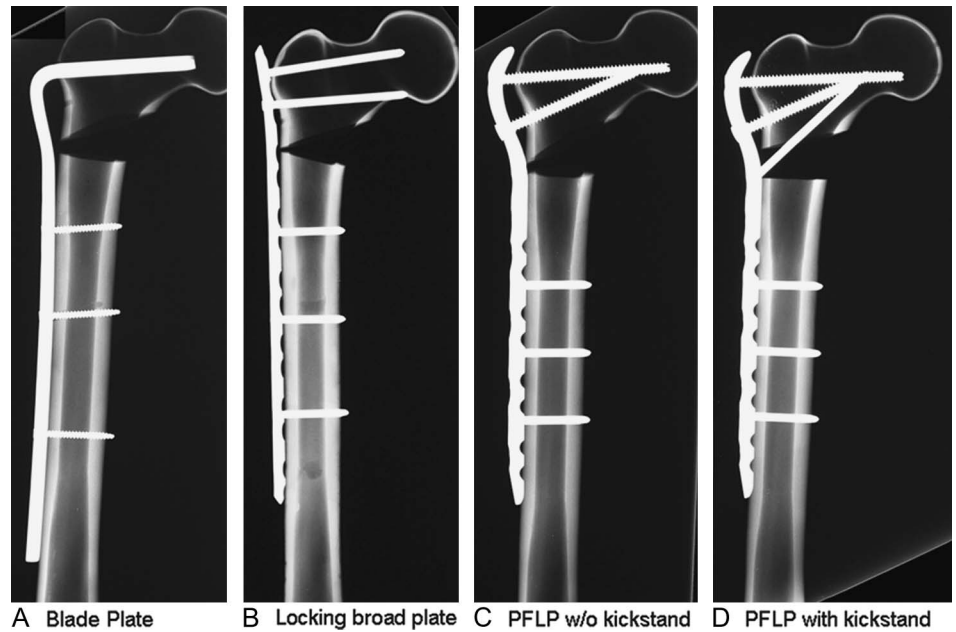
Implant construct radiographs. A, Blade plate. B, Locking broad plate. C, PFLP without kickstand. D, PFLP with kickstand.
